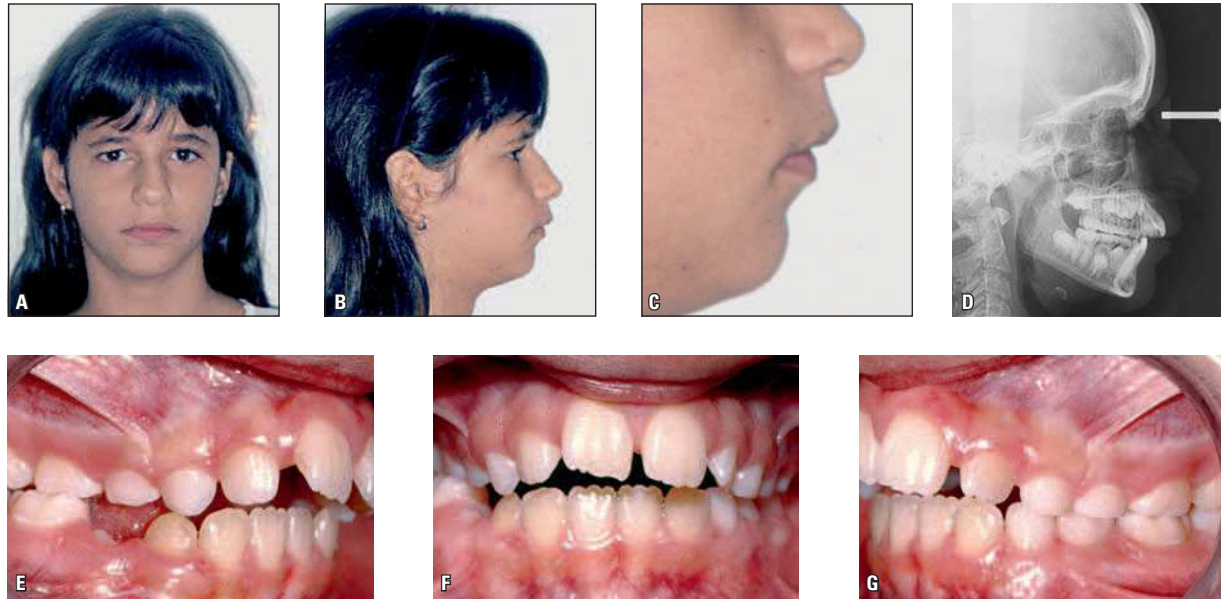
Initial extraoral photographs (A, B, C), cephalometric radiograph (D) and intraoral photographs (E, F and G).
